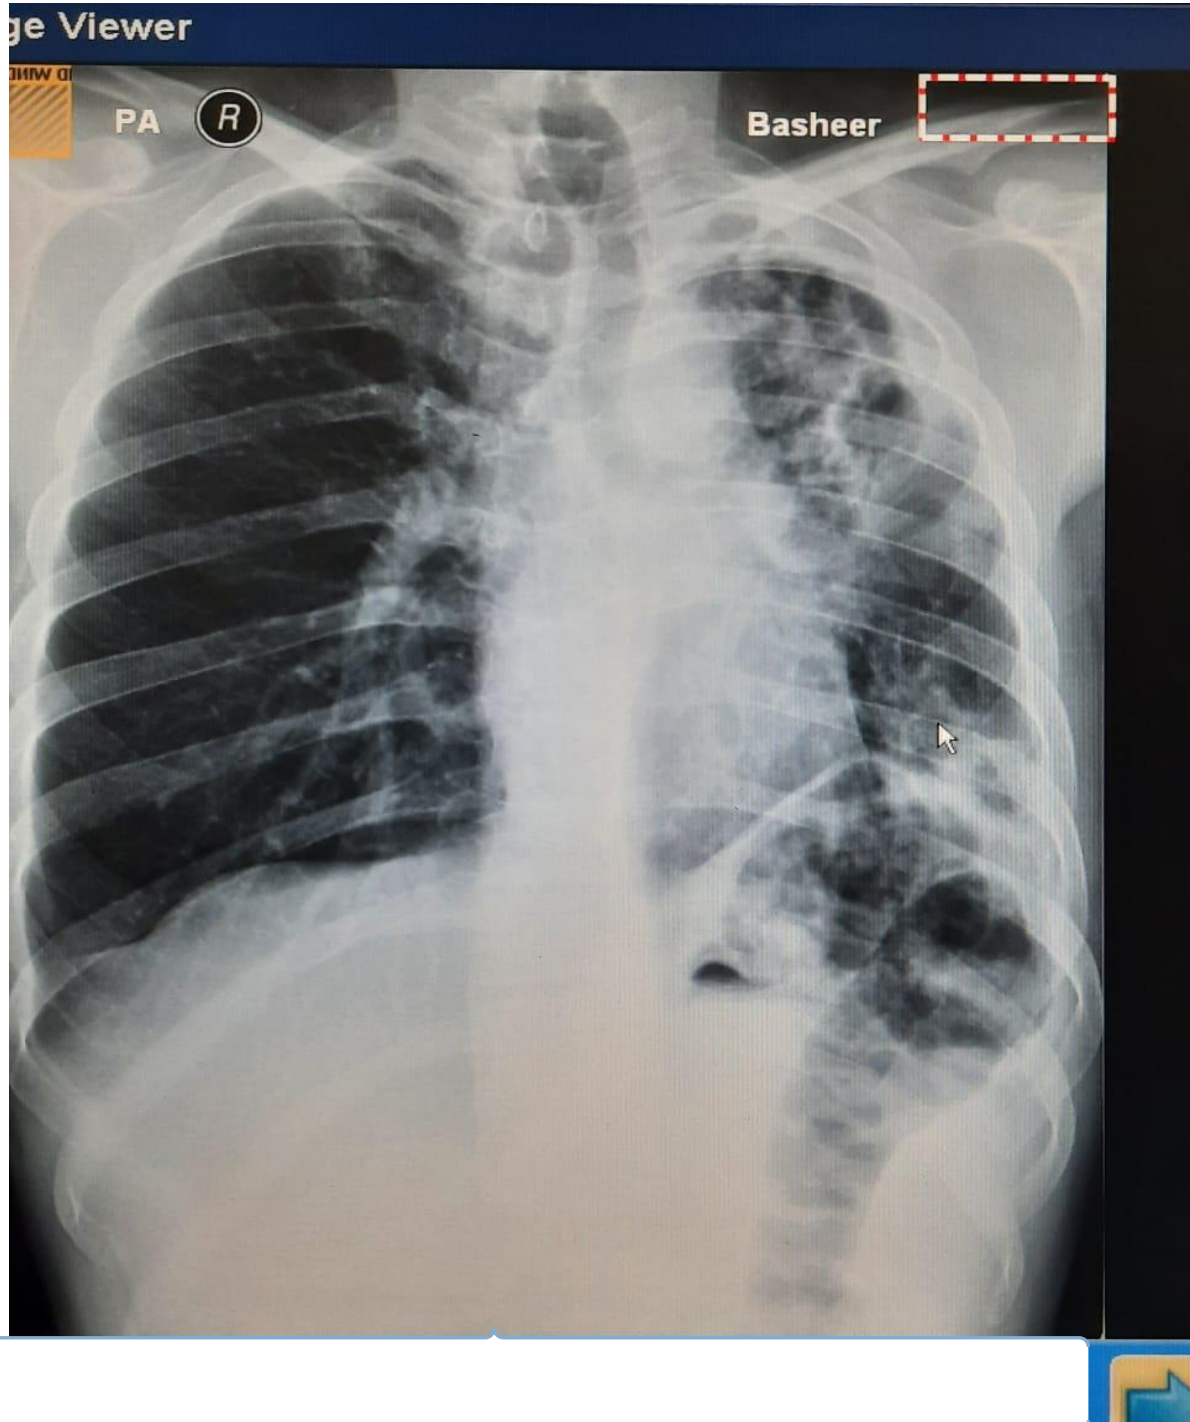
Show X-Rays for lung to patient who is infected by *Mycobacterium tuberculosis* disease which it resistance to TB drugs.
